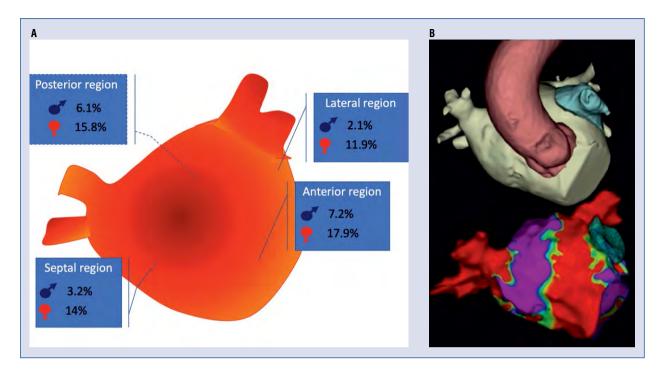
A. Mean distribution of left atrial fibrosis in subjects with > 5% fibrosis divided for male (blue) and female (red). B. Three-dimensional reconstruction of the left atrium and aortic position by voltage mapping and corresponding computed tomography-scan.
